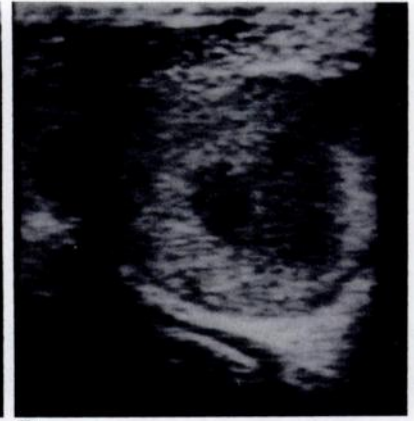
Longitudinal sonogram of 50-year-old man with nontender swelling of left testis shows an enlarged testis with generalized reduced echogenicity.
